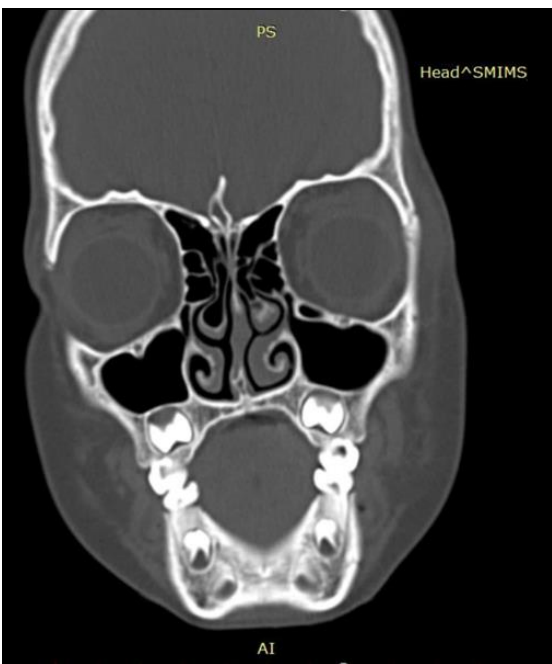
coronal section of CT PNS shows haller cell (Left side)
